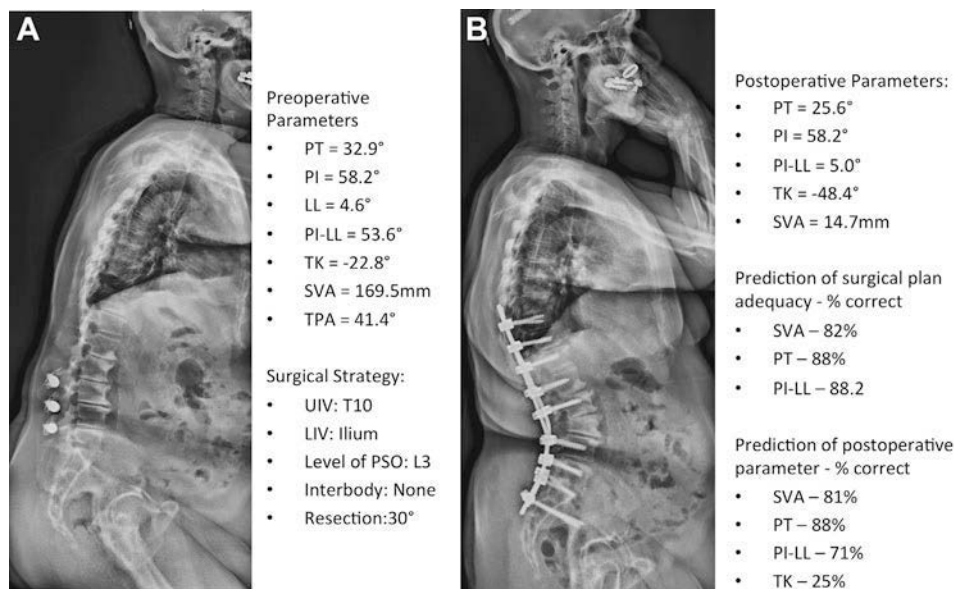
Sample survey case. (A) Preoperative standing long-cassette radiograph with standard spinopelvic parameters and surgical plan. (B) Postoperative long-cassette radiograph (not part of survey) with spinopelvic parameters and correct response rate for predicting adequacy of surgical plan and values of individual parameters.
